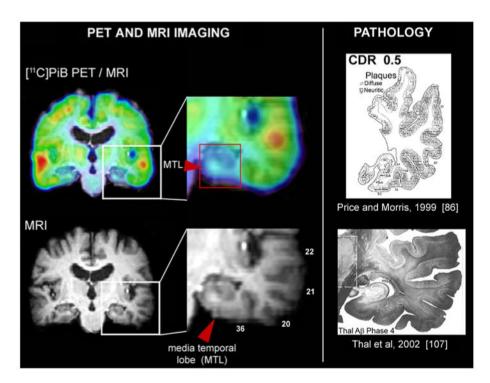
Lack of binding in medial temporal lobe structures in 11 C-PIB PET scan of an AD patient. Comparison of 11 C-PIB PET scan (*upper left*) and MRI scan (*lower left*) reveals that medial temporal lobe 11 C-PIB signal is significantly lower than in other cortical structures. Detailed view of temporal lobe (*middle column*) clearly shows that 11 C-PIB signal is low not only in hippocampus but also in hippocampal gyrus and occipitotemporal gyrus, both areas of medial temporal lobe that have Aβ levels comparable to the levels observed in other parts of temporal lobe as shown on examples from AD pathology studies. Examples from Price and Morris [86] (*upper right*) and Thal et al. [107] (*lower right*). Distribution volume ratio (DVR) 11 C-PIB image in reference to cerebellum is shown. *Warmer colors* represent higher DVR values. *MTL* medial temporal lobe
